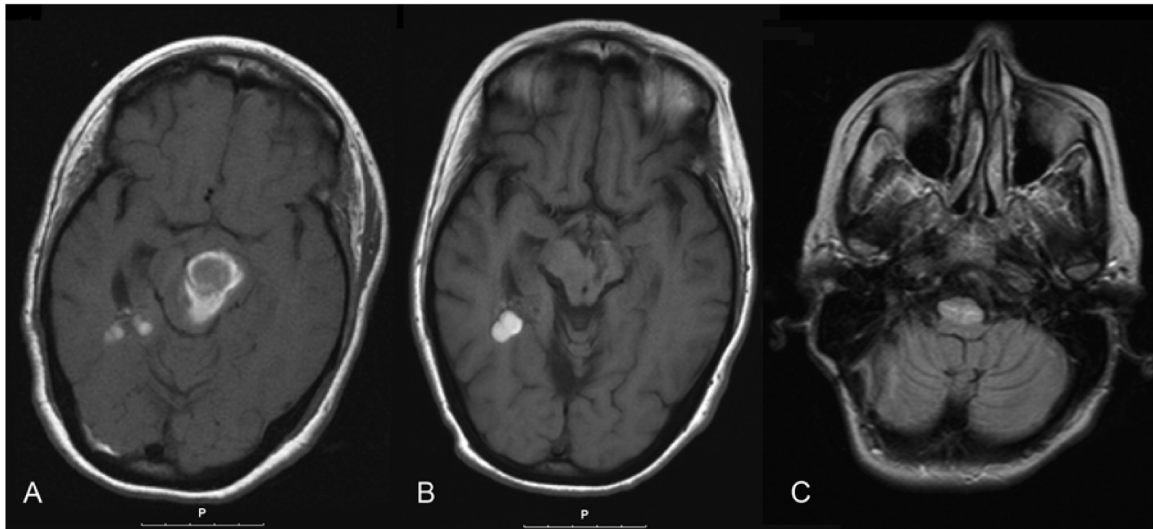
MR imaging of patient 4. (A) Axial, unenhanced T1-weighted MR image demonstrates preoperative location of cavernous malformation within the left mesencephalon. (B) Axial, unenhanced T1-weighted MR image obtained 6 months postoperatively demonstrates the unremarkable changes in the resection bed and improvement of mass effect. (C) Postoperative axial FLAIR MR image obtained 18 months after intervention shows increased signal intensity within the lateral aspect of both sides of the medulla with enlargement of both inferior olivary nuclei; bilateral HOD.
